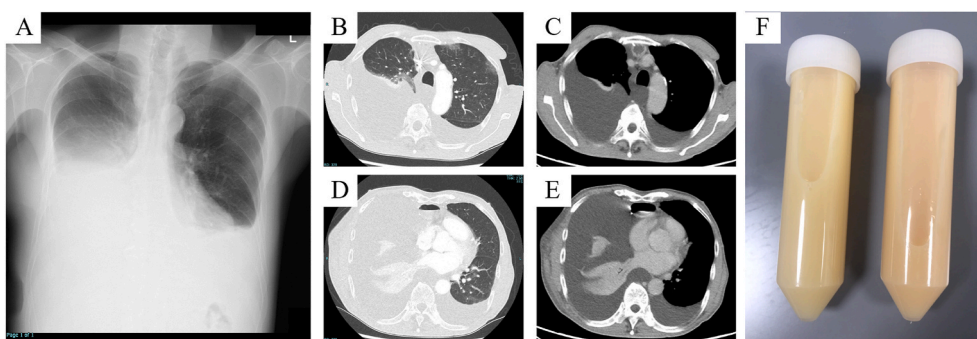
(A) Chest X-ray upon admission reveals bilateral pleural effusions. (B–E) Chest computed tomography reveals bilateral pleural effusions and ascites. Additionally, edema is visible in the right chest wall. (F) The pleural effusion aspirated through thoracentesis upon admission demonstrates chylothorax.
